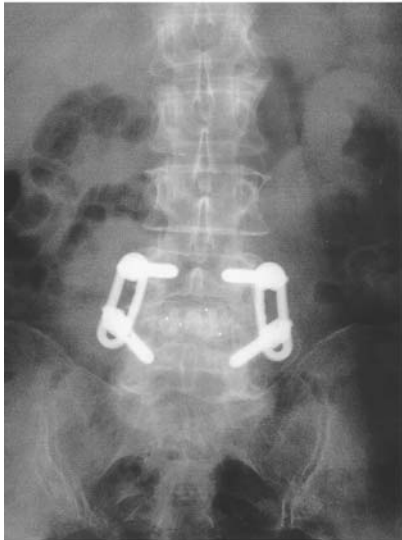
Continued. (E) A-P x-ray film just after surgery; (F) lateral x-ray film just after surgery; (G) A-P x-ray film 10 months after surgery; (H) lateral x-ray film 10 months after surgery.
